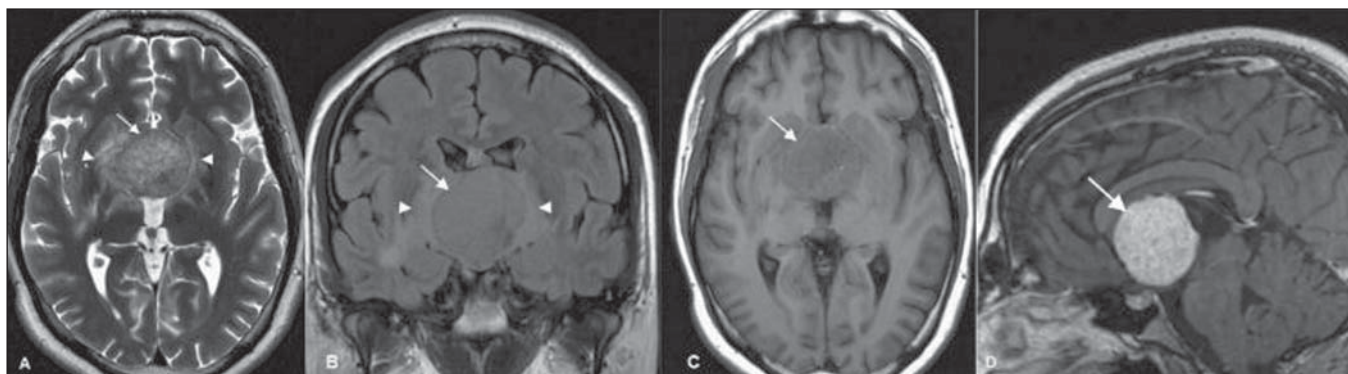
Axial MRI T2-weighted (A) and coronal FLAIR (B) sequences reveal a slightly hyperintense, well-defined hypothalamic/third ventricular tumor (arrows), with perilesional vasogenic edema (arrowheads). C: Axial MRI T1-weighted sequence reveals a predominantly isointense tumor (arrow). D: Gadolinium-enhanced sagittal MRI T1-weighted sequence reveals the tumor with uniform contrast enhancement (arrow).
